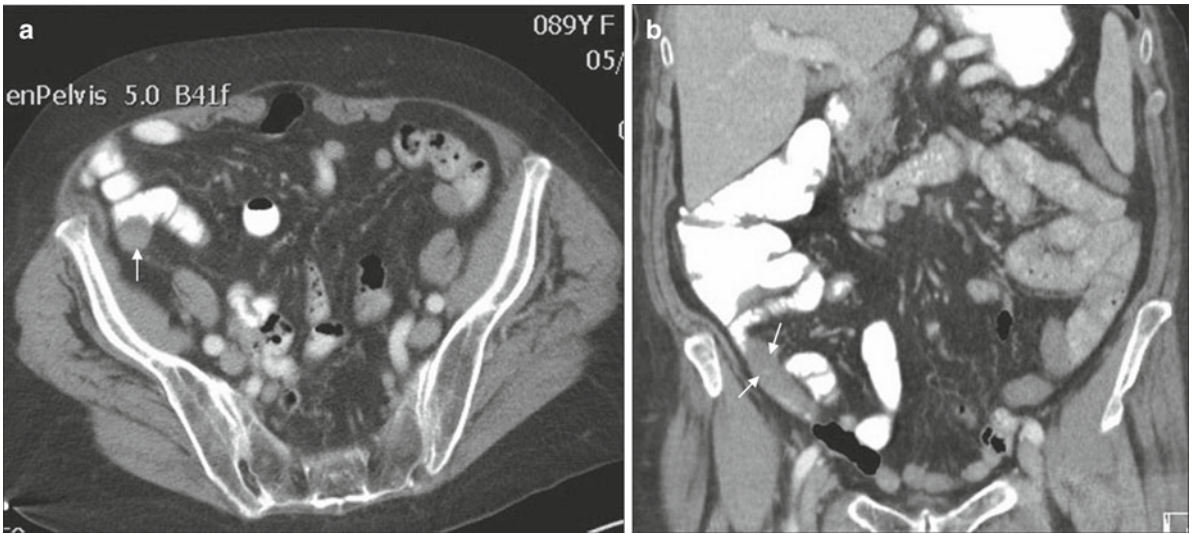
An 89-year-old woman with RLQ abdominal pain and tenderness. (a, b) Axial and coronal oral and intravenous contrast enhanced CT images through the lower abdomen and pelvis show a dilated
